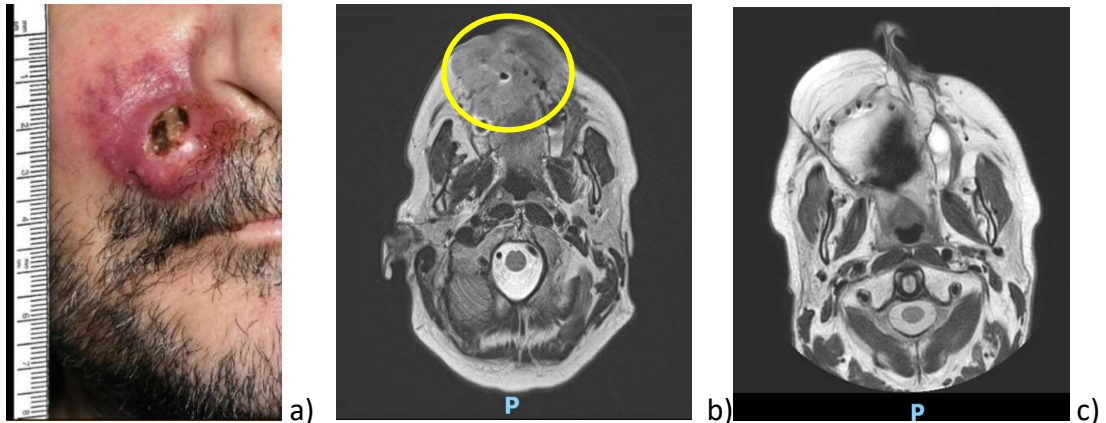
Patient 2 a) clinical photograph of maxillary alveolus SCC fistulating through skin prior to surgical resection. b) pre-treatment axial slice of MRI neck (T2 weighted) T4 right maxillary alveolus lesion shown (yellow circle). c) axial slice of MRI neck (T2 weighted) taken 12 months post surgical resection with reconstructed osseous free flap shown and no evidence of recurrent disease.
